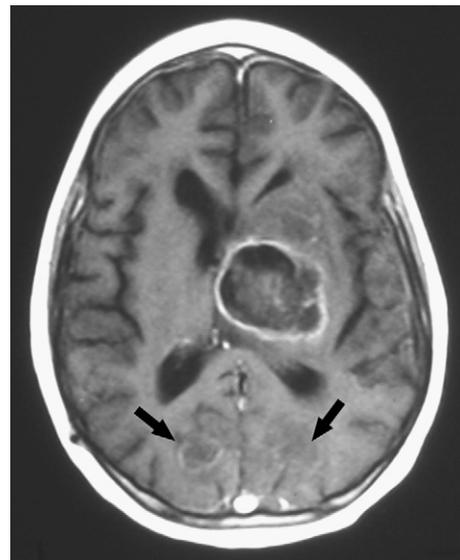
Aspergillus* brain abscesses. Axial T1-weighted image with gadolinium shows a large thalamic astrocytoma and faint ring-enhancing *Aspergillus* abscesses in the occipital lobes (arrows) (With permission from Rastogi H, et al. The posttherapeutic cranium. In: Jinkins JR (ed) Posttherapeutic Neurodiagnostic Imaging. Lippincott-Raven Publishers, New York, 1997, p.3.)
